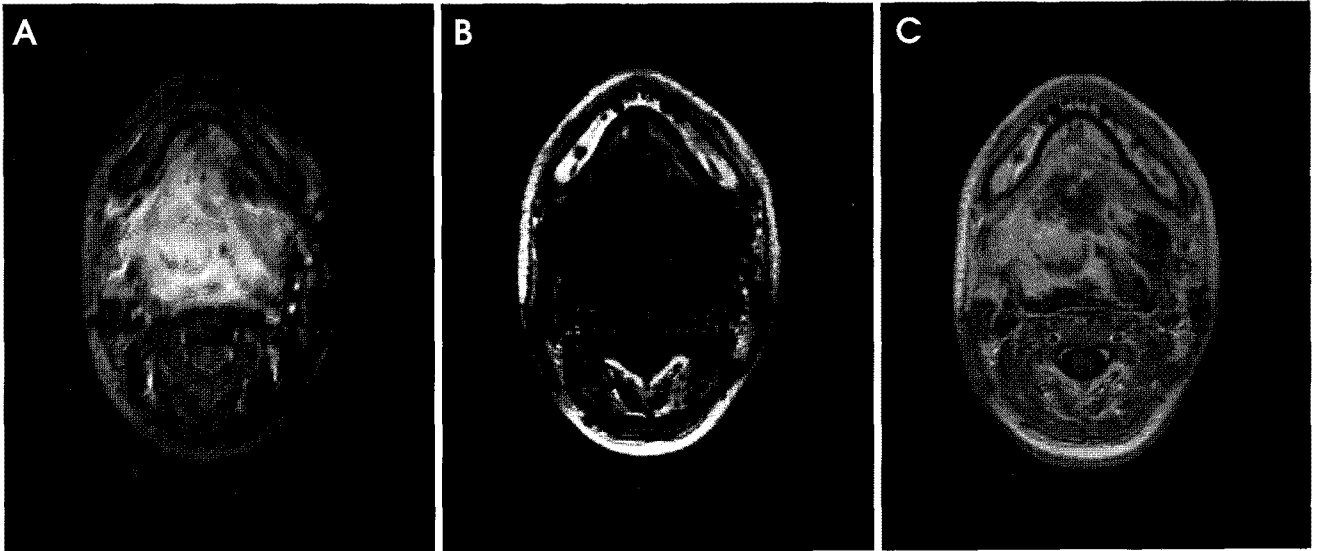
Preoperative MRI. (A) T2-weighted image shows a large volume of mass of the tongue base obstructing the airway. The mass has a heterogeneously high signal intensity and an ill-defined margin. (B) T1-weighted image shows a homogeneously low signal intensity lesion. (C) Enhanced T1-weighted image shows a heterogeneously well-enhancing lesion.
